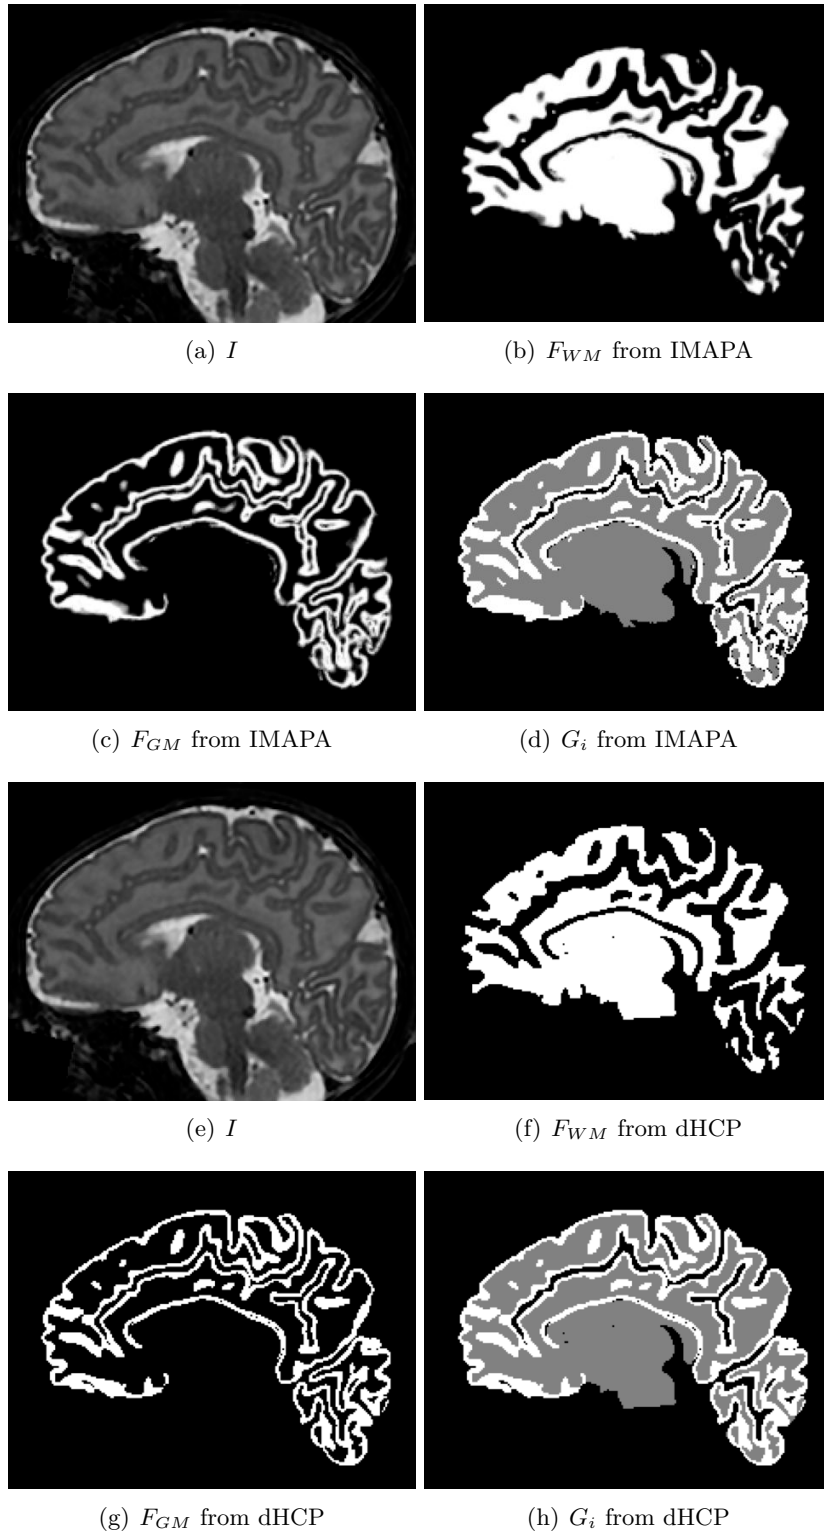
(a) & (e) MR image. (b) & (f) The WM map. (c) & (g) The GM map. (d) & (h) Crisp classification map (WM in grey; GM in white; CSF + background in black). (a–d) Data from fuzzy maps (IMAPA). (e–h) Data from hard maps (dHCP). (a–h) Sagittal slices.
